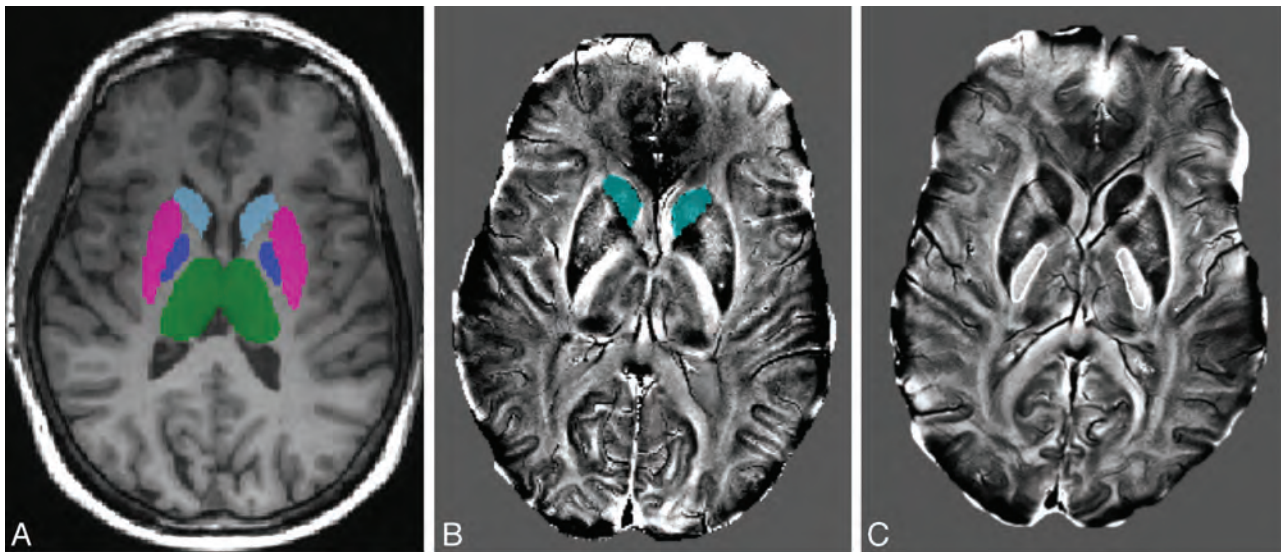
A, ROIs are extracted automatically from 3T T1-weighted images by using FSL; the segmented caudate nuclei from 1 subject are shown in light blue. B, Caudate ROIs are automatically coregistered with the 7T data and overlaid onto the phase images. C, PLIC ROIs drawn manually (thin region drawn on each side of the brain in white) on 7T phase images. Mean PLIC phase was used for normalization in the construction of LFS maps in each patient.
